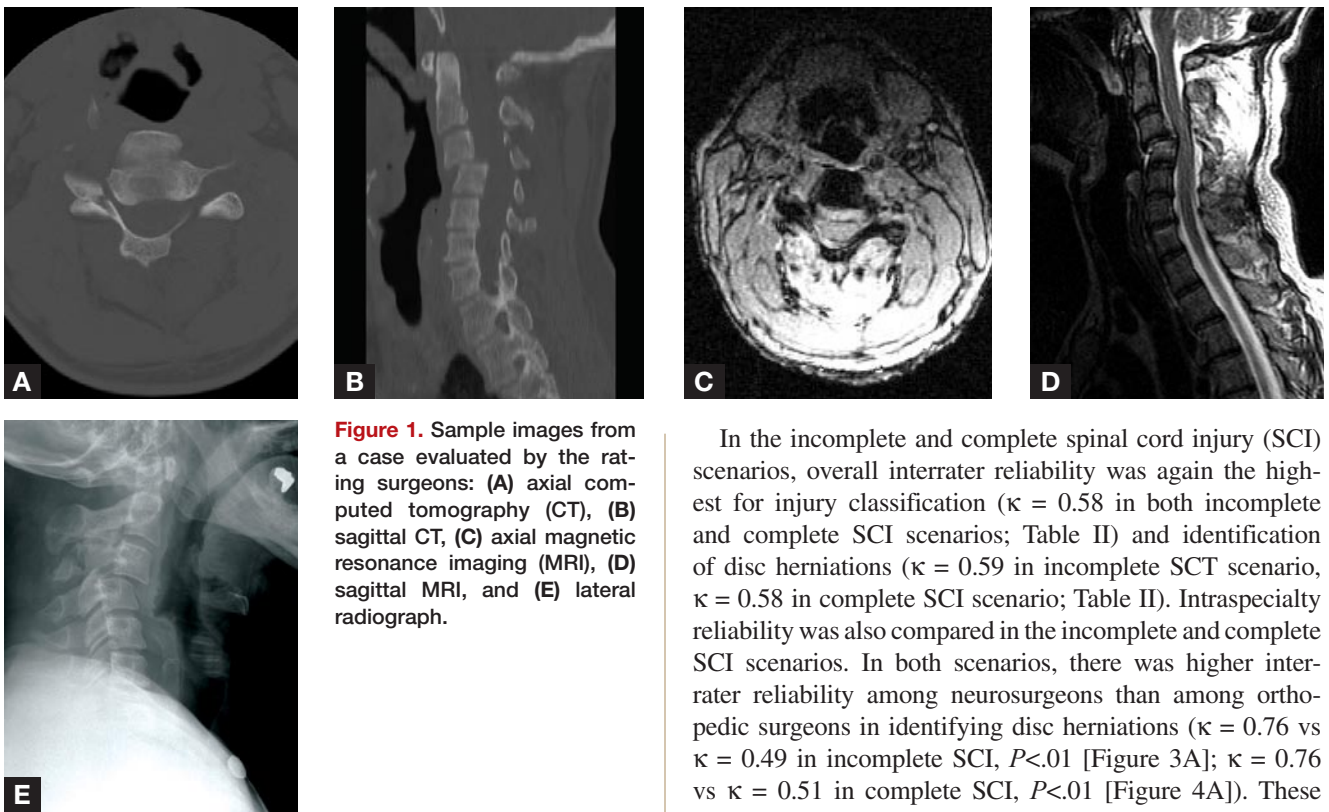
Sample images from a case evaluated by the rating surgeons: (A) axial computed tomography (CT), (B) sagittal CT, (C) axial magnetic resonance imaging (MRI), (D) sagittal MRI, and (E) lateral radiograph.
